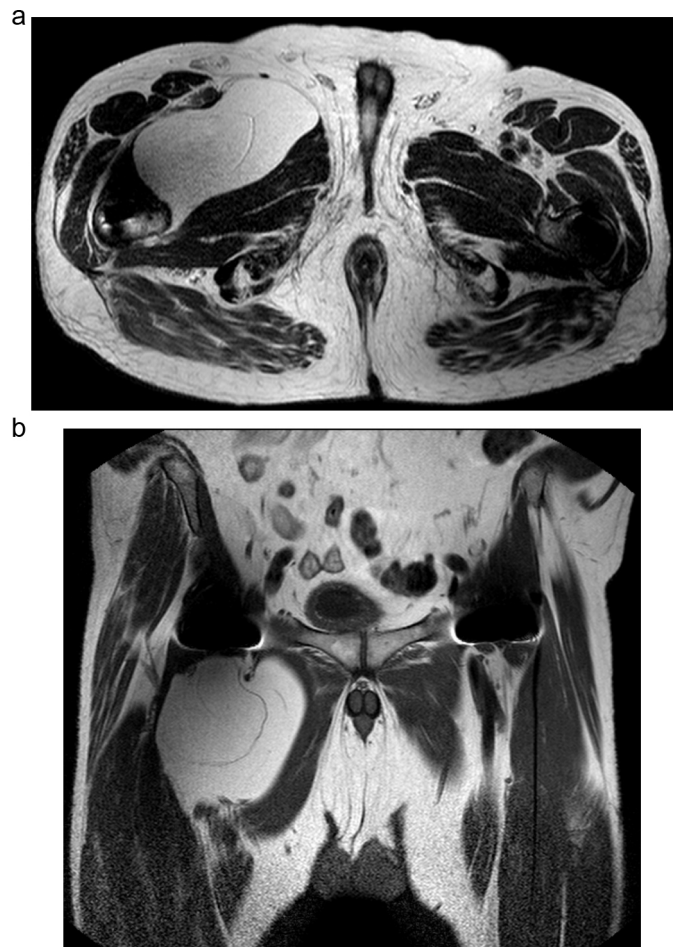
T1 weighted Magnetic Resonance Image (a) axial and (b) coronal view. The very large soft tissue mass is seen between alongside the right iliopsoas tendon.
